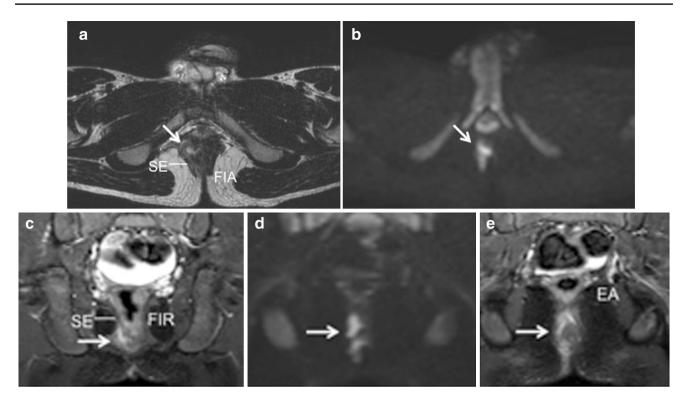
Grade 3 (Morris's) transphincteric fistula with an internal opening at 9-10 o'clock and which penetrates the sphincterial complex and in particular the external anal sphincter (SE) as shown on axial T2-weighted image (a) and on the corresponding axial DWIBs
